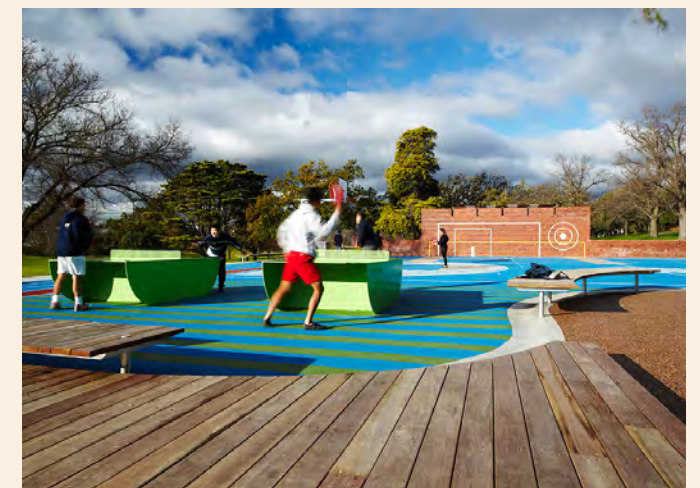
Box Hill Gardens by ASPECT Studios. Image Source: Andrew Lloyd
